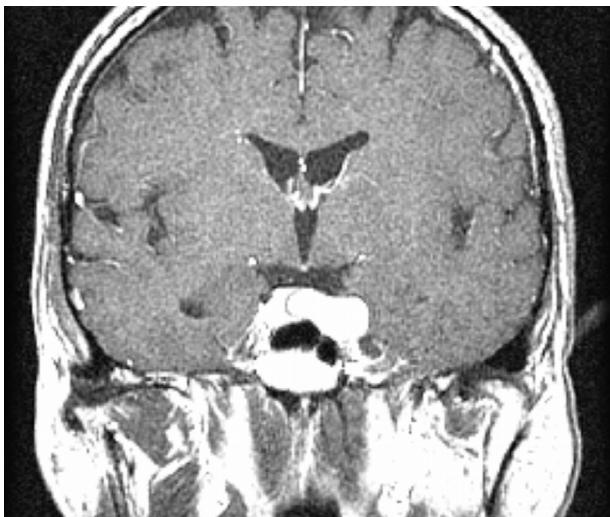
Preoperative coronal T1-weighted magnetic resonance (MR) images presenting tumour mass localised in the left cavernous sinus and sella turcica. Homogeneous contrast enhancement is seen.
